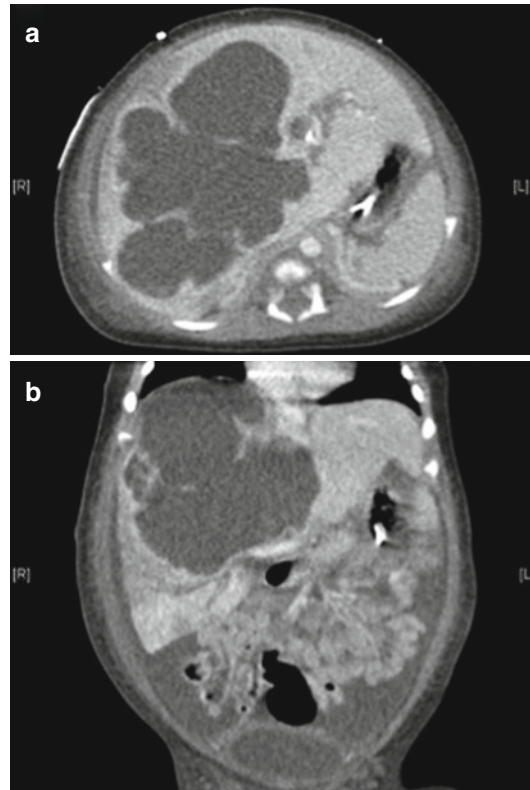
Massive extravasation of PN solution from an umbilical venous catheter which migrated into the liver – (a) axial and (b) coronal CT views
